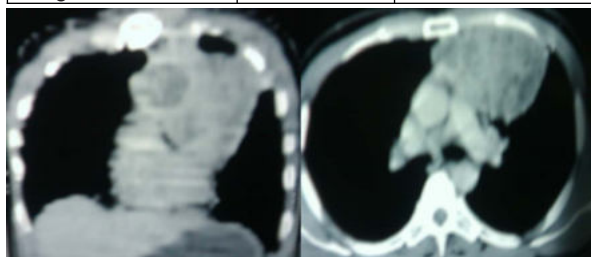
Thymoma: CT scan of thorax of different patients shows, lobulated, soft tissue attenuating mass appearing hypodense on non-contrast study. On post-contrast study it shows heterogeneous contrast enhancement.
